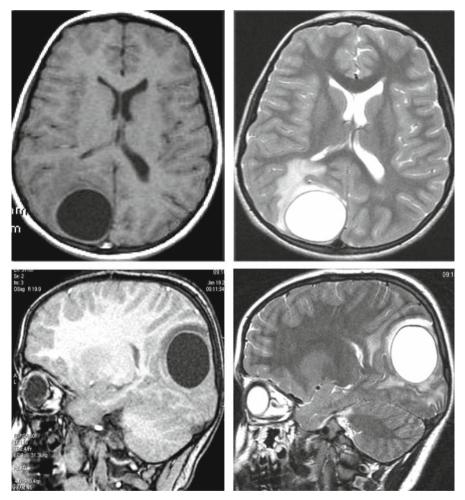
Upper and lower left: MRI pictures depict on axial and sagittal T1-weighted images a hypointense occipital mass with no shift. Upper and lower right: Slices on T2-weighted images show a hyperintense occipital mass with hypointense capsule with slight surrounding oedema
